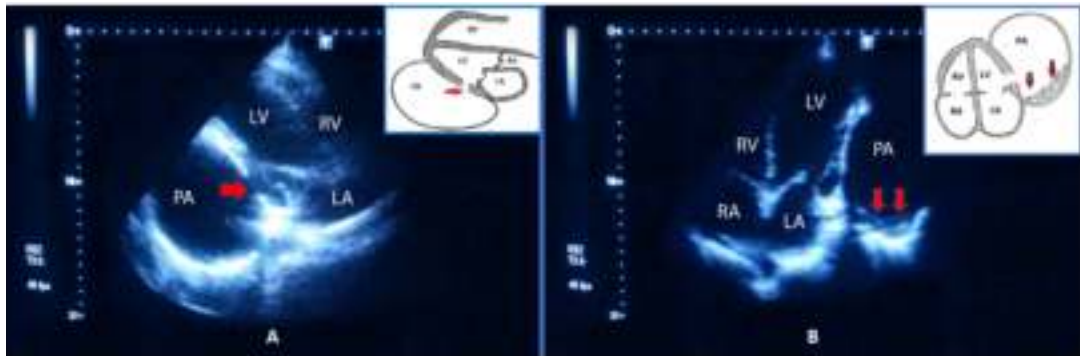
A. Echocardiogram in the parasternal long axis view and scheme. Thinning and wall rupture – a defect in the posterolateral left ventricular wall (arrow) through which the left ventricular communicates with the pseudoaneurysm. B. Echocardiogram in the apical four chamber position and scheme. Mural thrombi in the pseudoaneurysm cavity (arrows).
